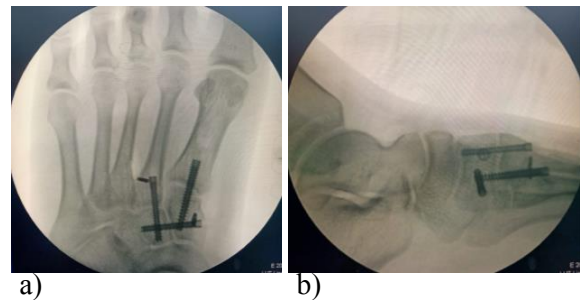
Left foot post-operative radiographs; (a) PA view showed the tightrope fixation at the native Lisfranc ligament; (b) lateral view showed reduced 1st and 2nd TMJ
